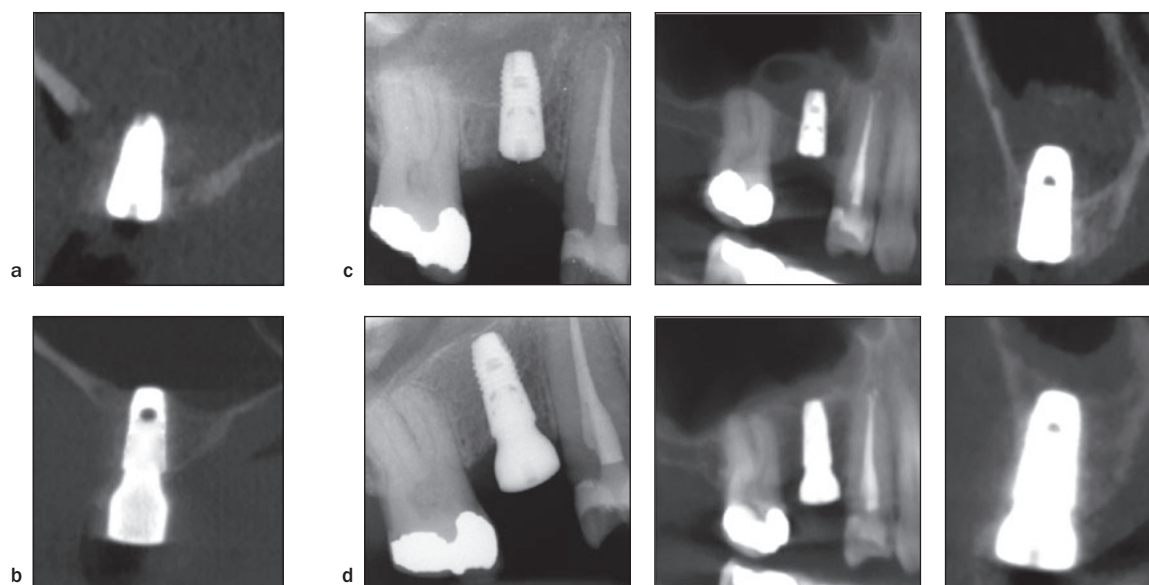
Cross-sectional CBCT slices and periapical radiographs. (a) Directly after implant insertion using the LSFE. (b) Six months after LSFE at abutment connection. (c) Directly after implant insertion using the TSFE. (d) Six months after TSFE at abutment connection.
